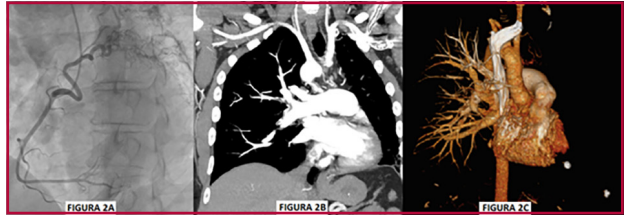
A. Coronary angiography. B. Computed tomography pulmonary angiogram. C. 3D reconstruction
